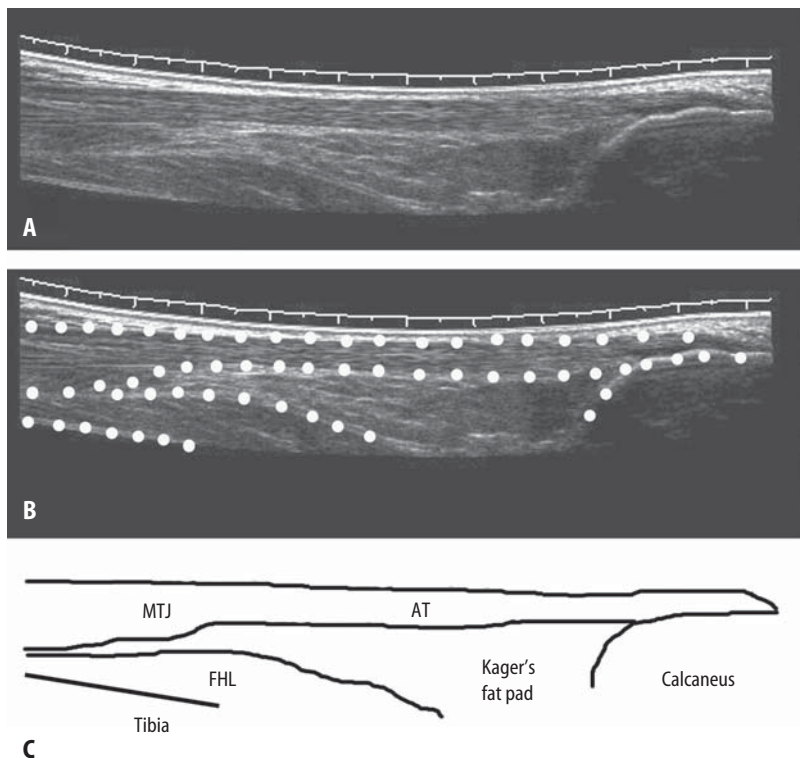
(A) Longitudinal ultrasonographic image of the Achilles tendon using extended field of view, from its soleal musculotendinous junction (MTJ) to its insertion on to the calcaneus. (B) Soft tissue interfaces marked by dotted line.
